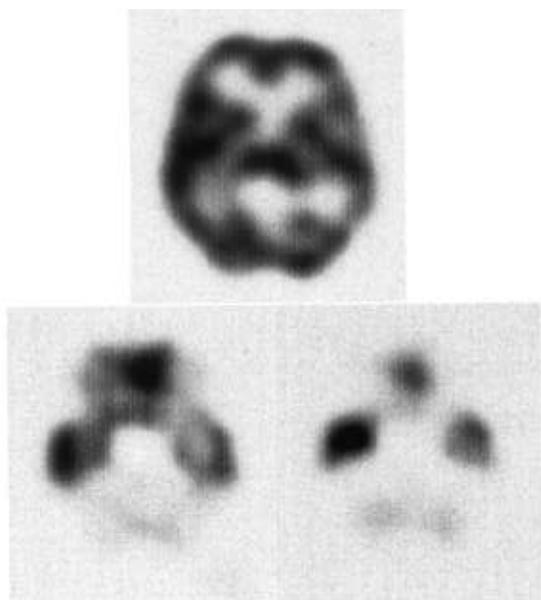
58-year-old female with OPCA. IMP SPECT shows severe decreased accumulation in the cerebellum and brainstem. The C/O ratio was 0.43, the B/O ratio was 0.25. (C: blood flow of cerebellum, B: blood flow of brainstem, O: blood flow of occipital lobes)
